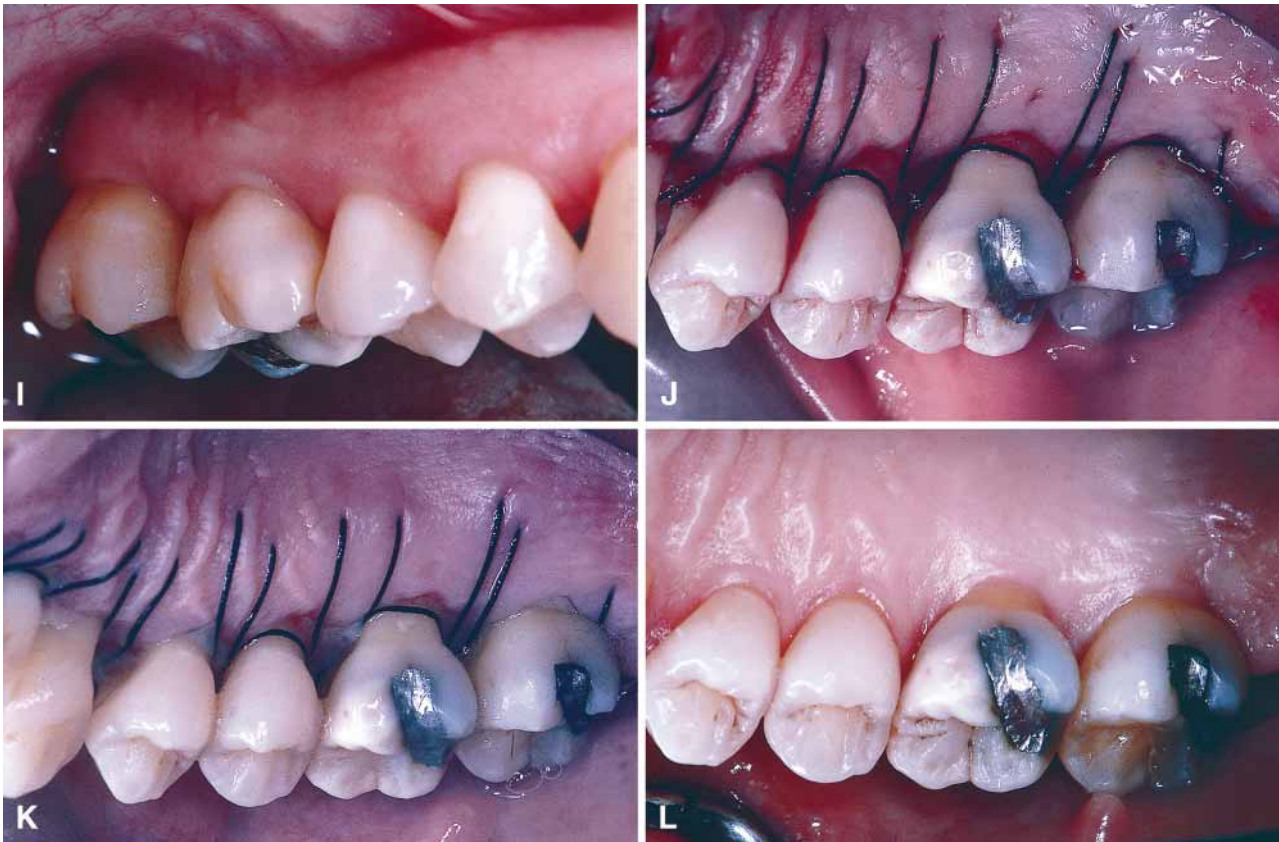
A. Radiographic examination of a 46-year-old woman diagnosed with advanced adult periodontitis. B. Radiographic examination of the maxillary anterior quadrant. Note extensive radiographic bone loss. C. Clinical appearance. Note supragingival plaque and heavy calculus. D. Buccal double-scalloped and scalloped incisions start at a distance from the gingival margin and is aimed apically at the osseous tissue to remove the inflamed tissue and create a flap margin for adaptation to the dentoalveolar unit. Double scalloped incision creates a triangular soft tissue within the healthy gingiva that protects the furcation area of multi-rooted molars during healing. E. Palatal scalloped incision. The incision starts at a distance from the gingival margin and is aimed apically at the osseous tissue. Due to the lack of soft tissue flexibility in the palate, a definitive scalloped incision should be performed. The shape of the incision follows the radicular morphology and the depth should be at the level of palatal osseous crest or slightly apical to that after osteoplasty and ostectomy are accomplished. F. Palatal scalloped incision. The scalloped incision removes the inflamed tissue and creates a thin flap
